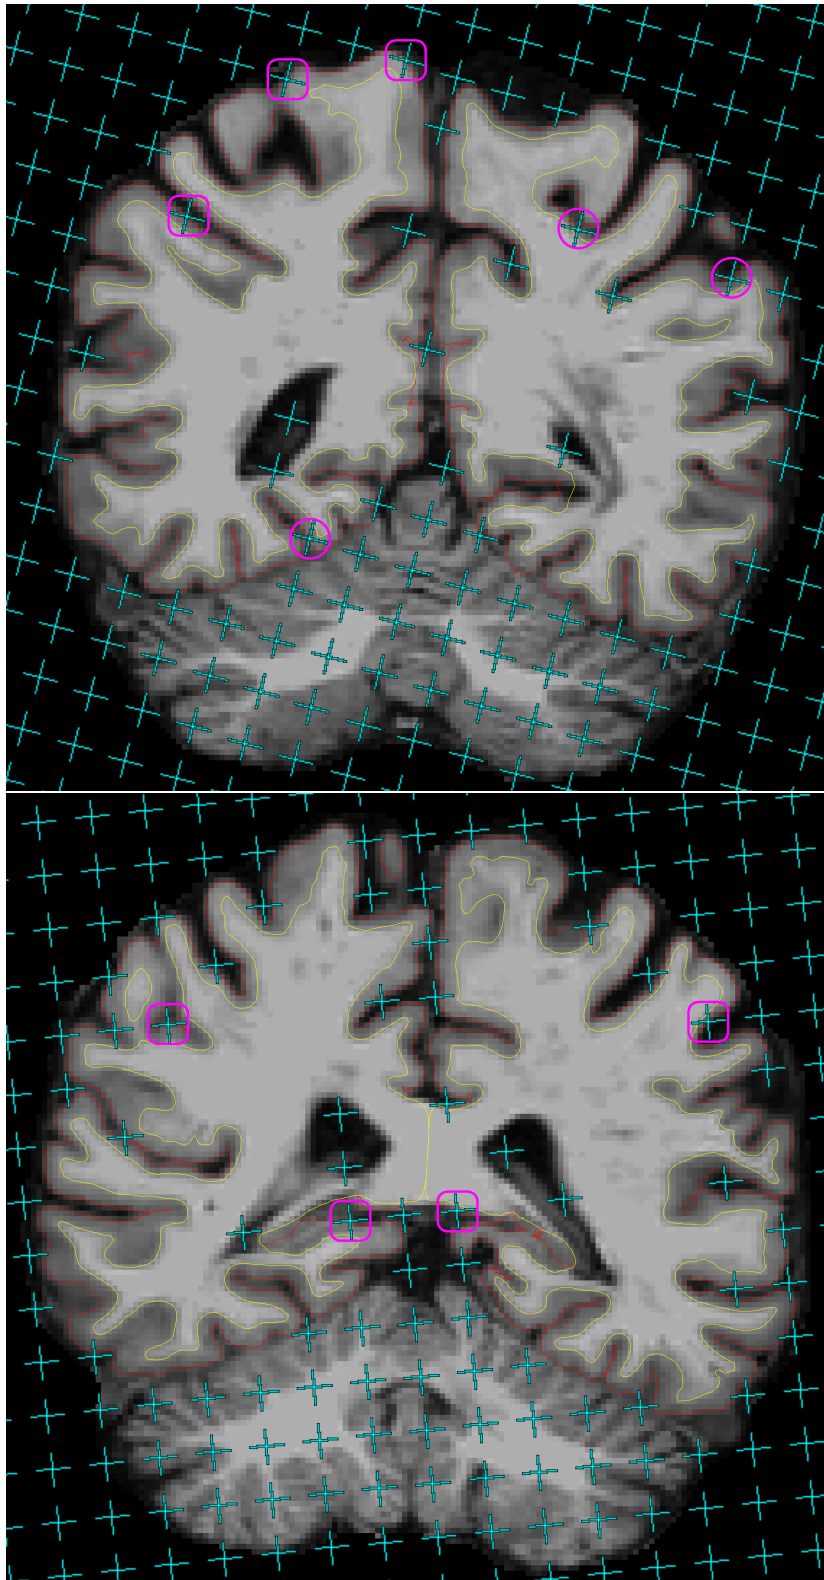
On the 6th and 7th slices of one brain MR image in the coronal view, uncounted test points (cyan) which miss the cerebral parenchyma or hit the ventricles are overlaid onto pial profiles (red lines) segmented by FREESURFER. Circles (pink) mark the uncounted test points which fall inside the grey matter boundaries (red lines) and rounded rectangles (pink, racetrack-like) mark the test points hitting exactly on the grey matter boundaries.
